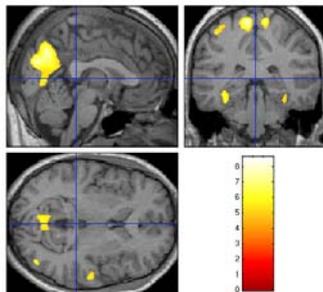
Areas of significant gray matter volume decrease in CAE subjects overlaid on a standard normalised MR image.
